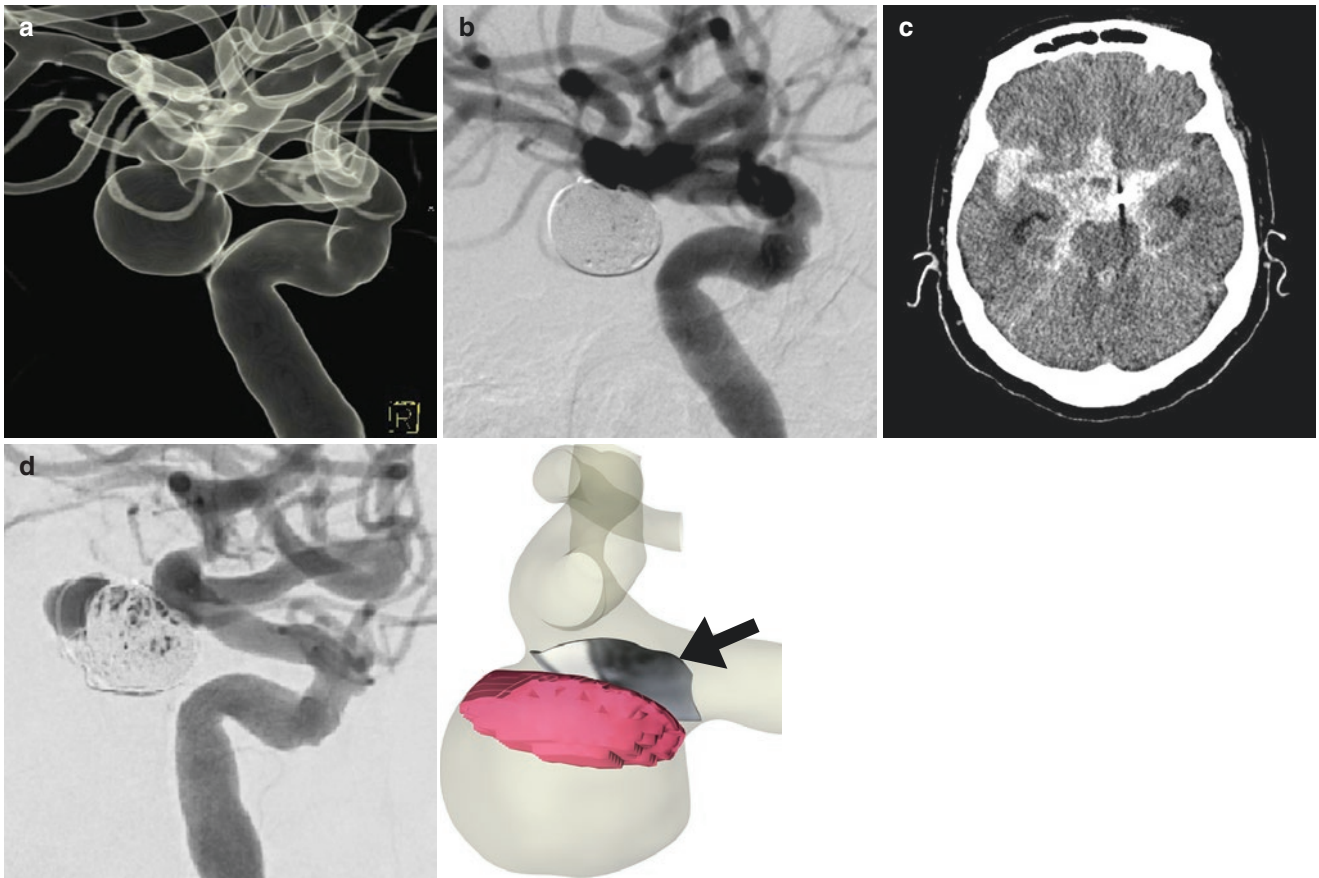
Seventy-nine-year-old woman with left internal carotid artery-posterior communicating artery bifurcation aneurysm: (a) 3D surface rendering image of rotational angiography; (b) angiography after stent-assisted coiling of the aneurysm with a packing density of 35.9%; (c) head CT revealing subarachnoid hemorrhage 19 months after the coiling; (d) left internal carotid artery angiography revealing the recanalization of the coiled aneurysm; (e) retrospective CFD findings using
